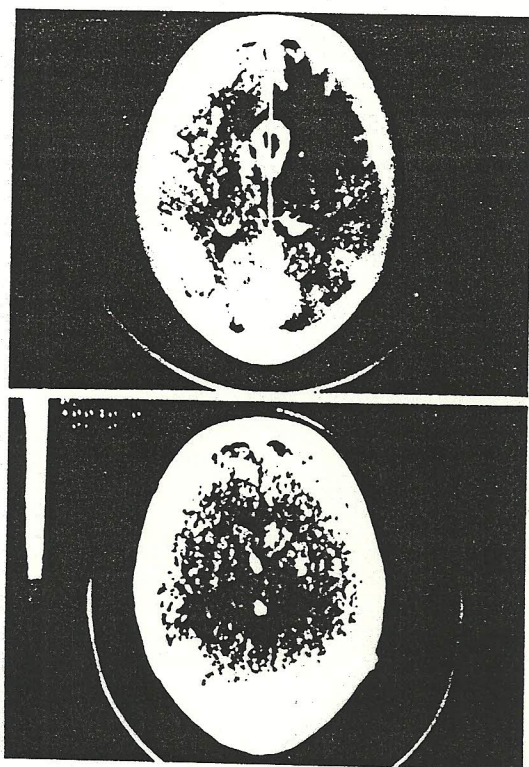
CT images of the brain of patient number 3 with neurocysticercosis. Note the presence of lesions prior to treatment with *Ruta graveolens* Linn. and Calcium phosphate (above), but disappearance of lesions after treatment (below).
